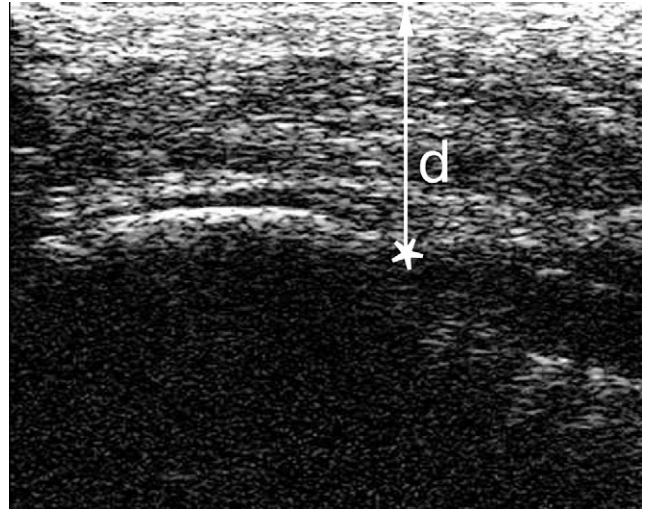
Longitudinal sonography of the calcaneus of one of the subjects. The asterisk shows where the PA originates at the inferior border of the calcaneus. The depth (d) of the PA origin (PA_o) is measured as the distance from the asterisk to the top of the image, where the probe is in contact with the sole of the foot.
